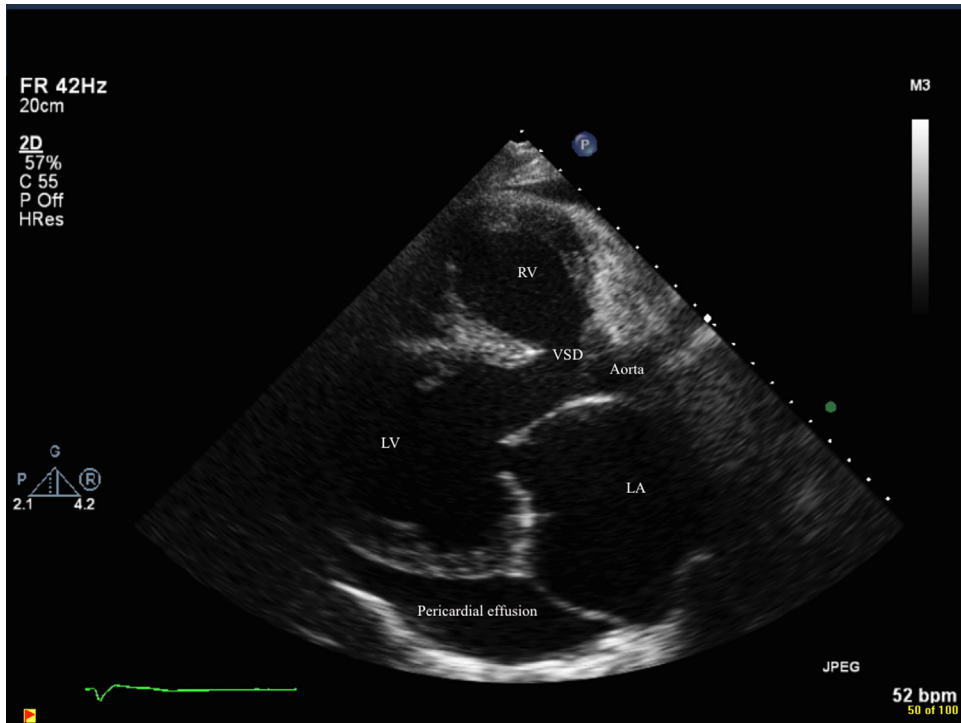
Preoperative transthoracic parasternal long-axis view demonstrating the VSD and overriding aorta in tetralogy of Fallot. LA, left atrium; LV, left ventricle; RV, right ventricle; VSD, ventricular septal defect.
